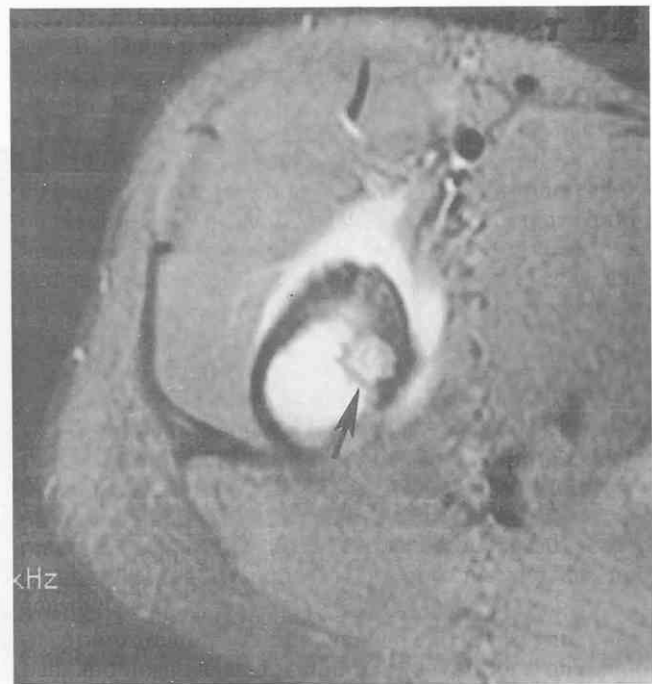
Osteoid osteoma of the proximal femur in an 8-year-old boy. Postgadolinium axial T1-weighted image (TR = 750 msec, TE = 12 msec) with fat saturation shows the nidus at the inner margin of the medial cortex (arrow). Marked enhancement is seen within the adjacent medullary cavity and extraosseous soft tissues.
